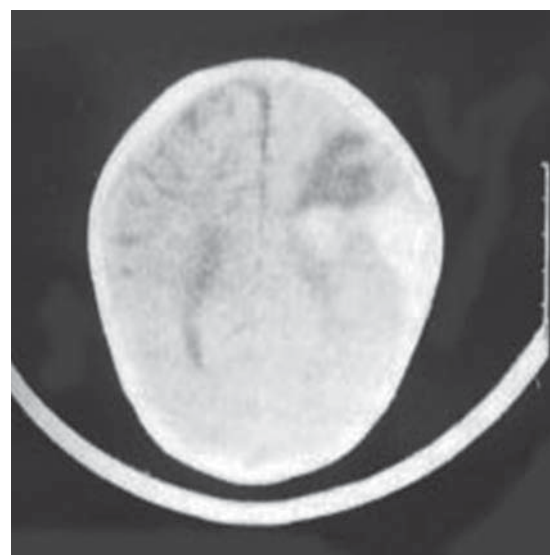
Computed tomography scan showing intracerebral hemorrhage in a child with left-sided hemiplegia.
